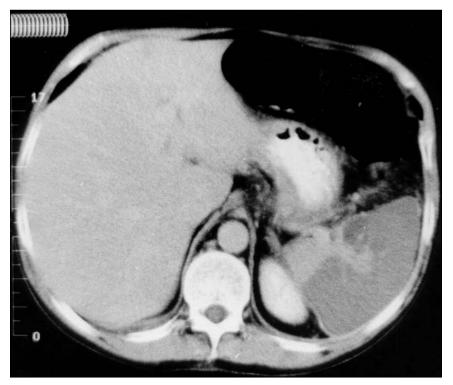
Computed tomography scan of the abdomen showing marked, low attenuation changes involving approximately half of the spleen, consistent with large splenic infarction.
